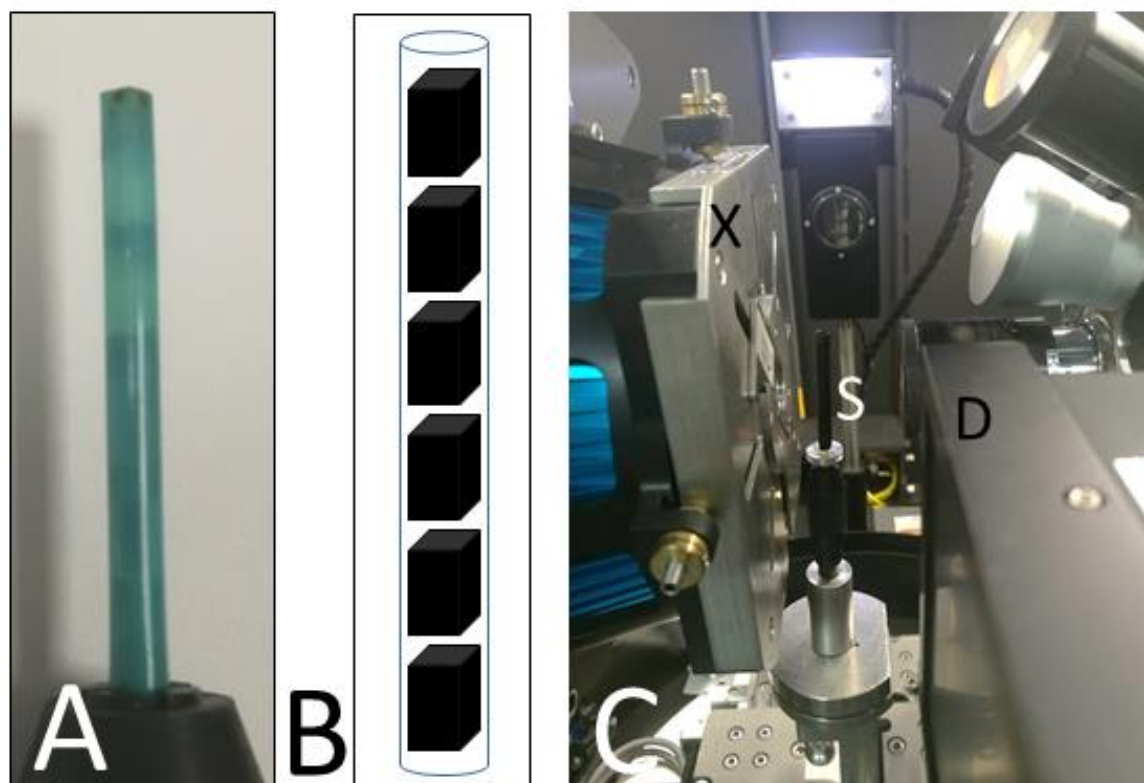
Set up for CT scanning.
